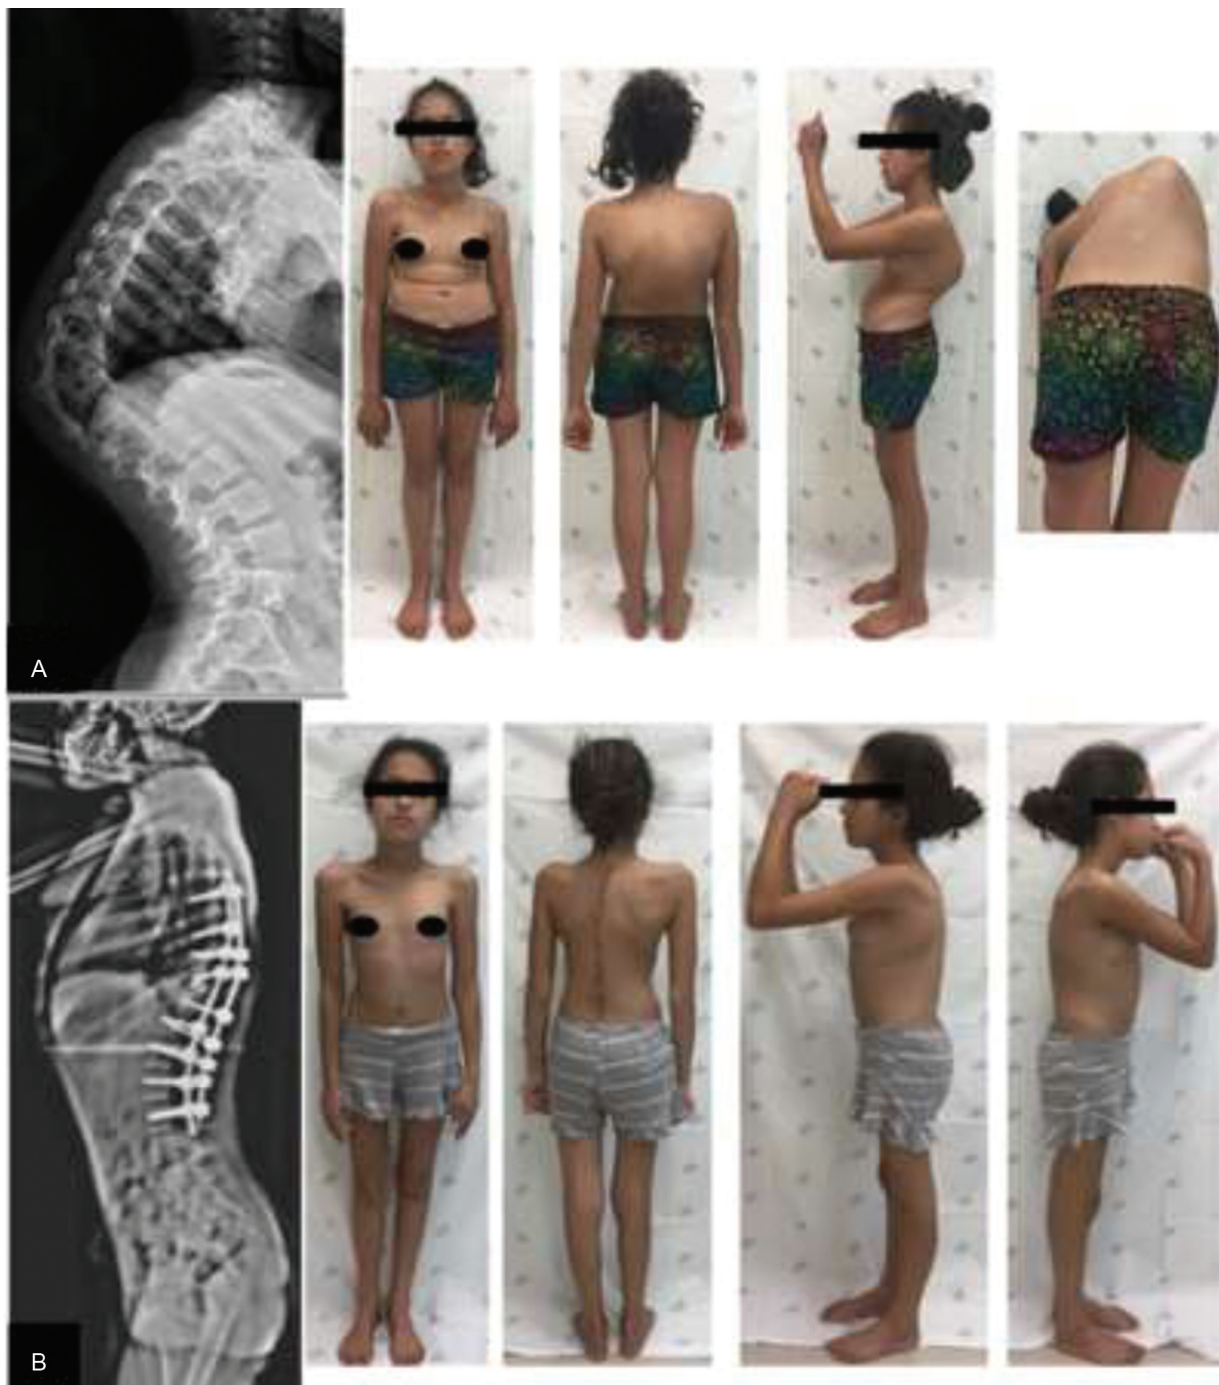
Pre (A) and postoperative (B) radiographic and clinical images of a patient with congenital kyphoscoliosis (patient 3), in which the customized guide was used.
